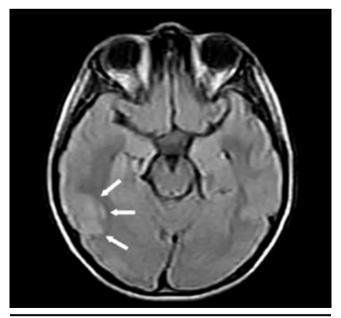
Hyperintense lesion (white arrows) leading to mild sulcal effacement localized in the cortico-subcortical region in the right temporooccipital lobe on T2 FLAIR images
